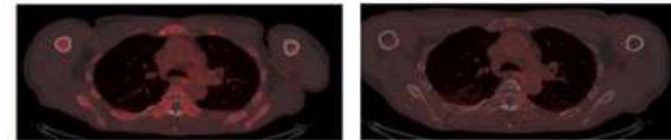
FDG PET/CT before (left) and after (right) KRd treatment. Several osteolytic lesions show decreased uptake after treatment.
